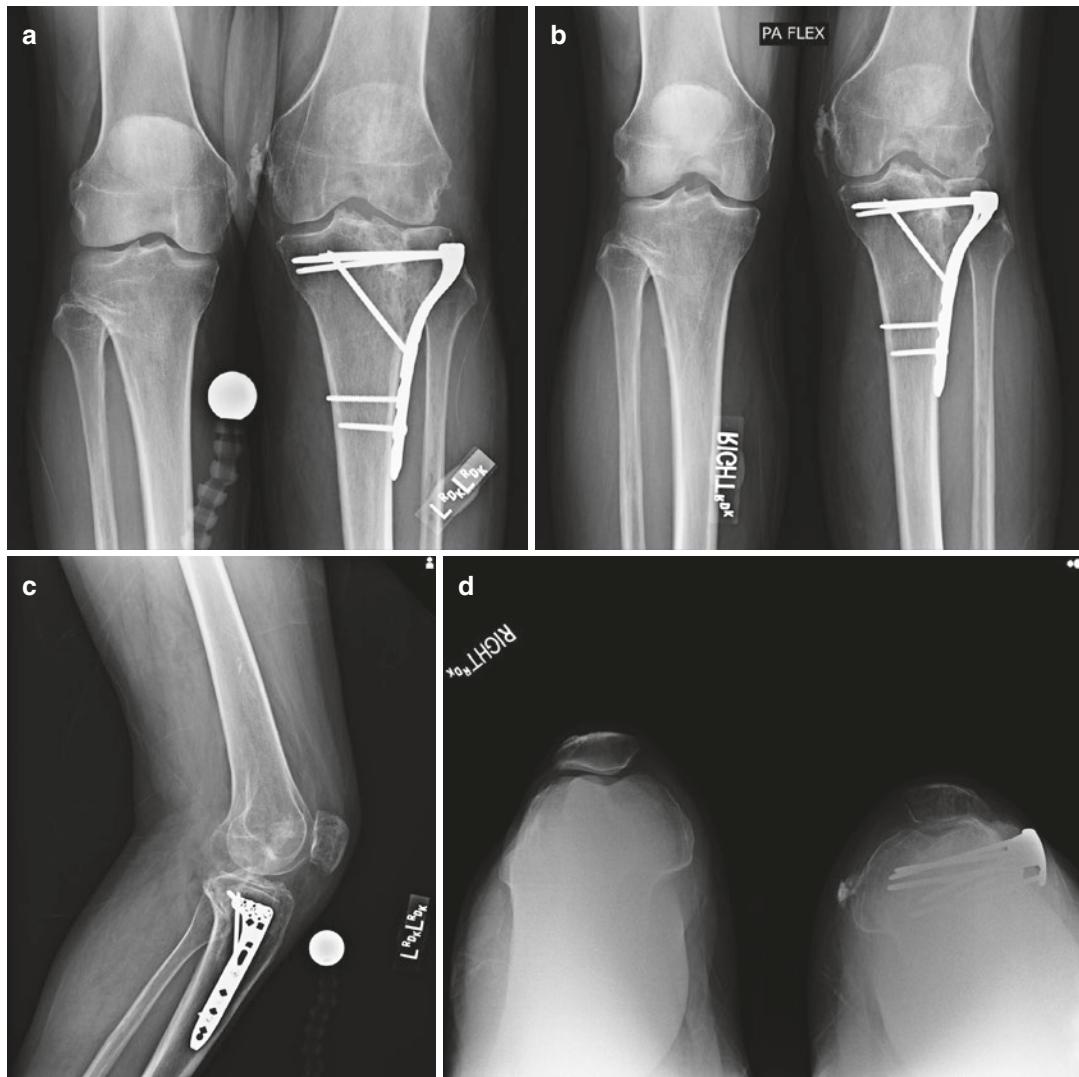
Radiographs prior to removal of hardware: (a) standing anteroposterior view of both knees, (b) posterior to anterior view of both knees in 40° of flexion, (c) lateral view of the left knee, (d) merchant patellar view of both knees
